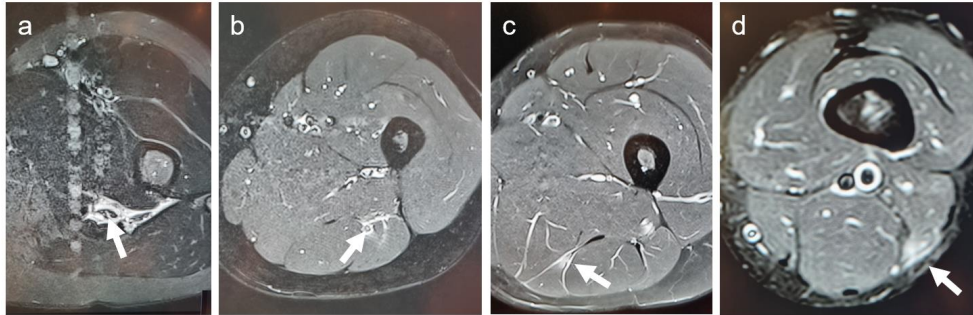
Axial proton density-weighted fat saturated MRI of injuries classified as (a) grade 2 injury in the proximal tendon of m. semimembranosus, (b) grade 2 injury in the proximal muscle-tendon junction of m. biceps femoris long head, (c) grade 1 injury with myofascial involvement in the proximal muscle belly of semimembranosus, and (d) grade 1 injury in the distal muscle-tendon junction of m. biceps femoris long head.
